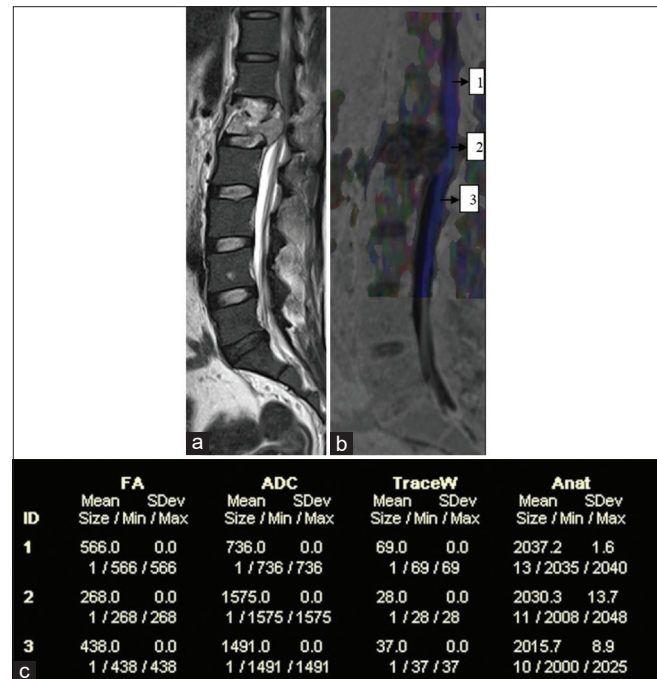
(a) Magnetic resonance imaging T2-weighted sagittal image in a trauma patient showing compression fracture of lumbar vertebra. (b) Diffusion tensor imaging image showing placement of three regions of interest at, above, and below the level of injury. (c) Chart showing reduced fractional anisotropy and raised apparent diffusion coefficient values at injury level
